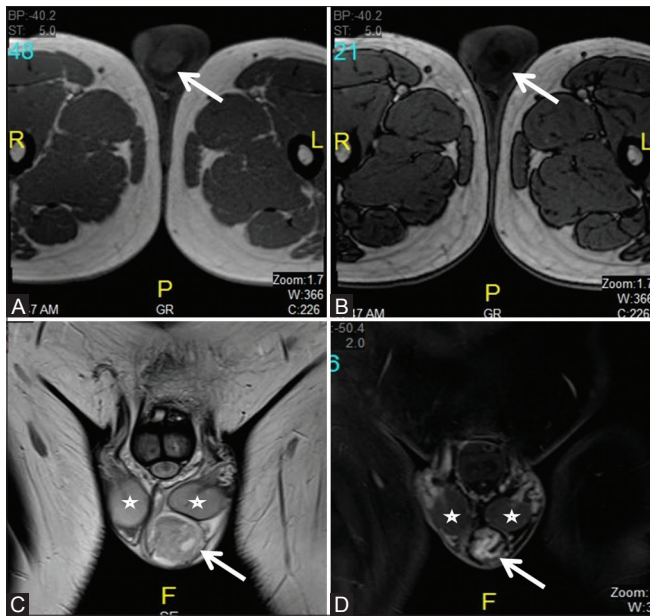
(A-D): (A) In-phase and (B) Out-of-phase images from chemical shift MRI shows signal drop within the mass (arrow). (C) Coronal T2-weighted MRI shows heterogeneous hyperintense mass (arrow) in the left hemiscrotum separate from the testis (asterisk). (D) Postcontrast T1-weighted MRI shows heterogeneously enhancing mass (arrow) in the left hemiscrotum separate from the testis (asterisk)
